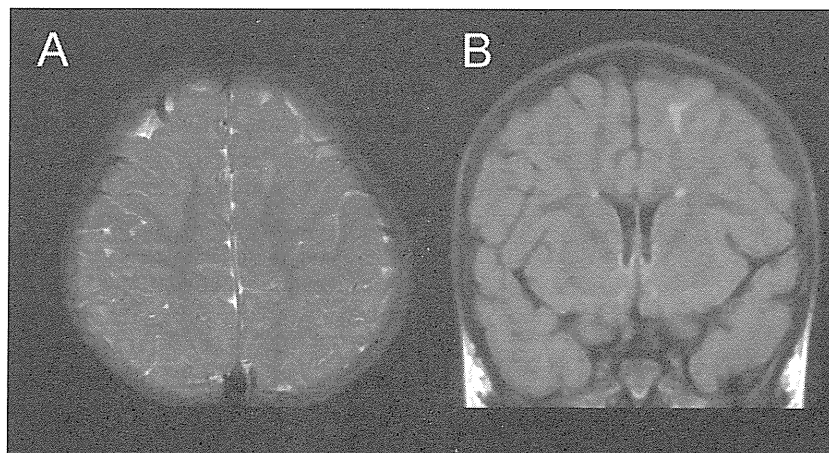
MRI image of brain. Axial T2 weighted (A) and coronal FLAIR (B) images show focal high signals in white matter including U-fibers.
